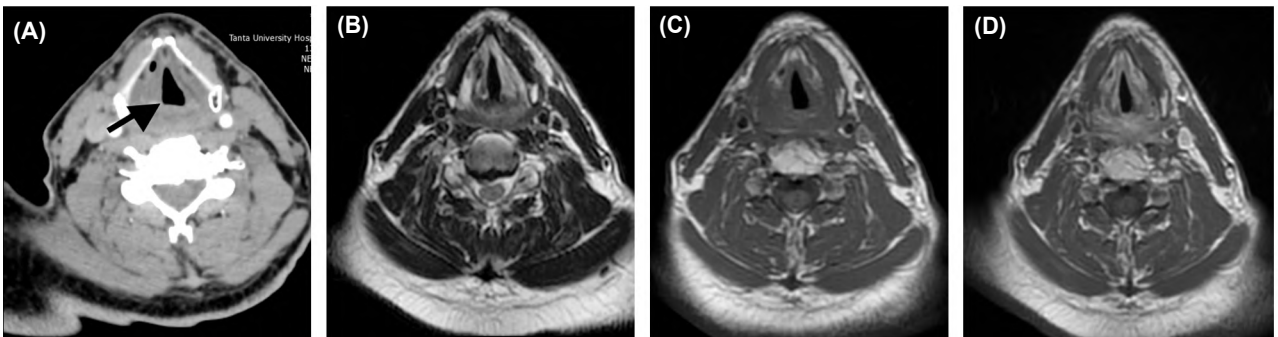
(A, B, C and D); A Male patient aged 55 years presented with hoarseness of voice. (A) Post-contrast CT axial view at the glottic region, (B) Axial T1-weighted image. (C) Axial T2-weighted image. (D) Axial post-contrast T1-weighted image. CT neck with contrast revealed asymmetrical right vocal cord thickening (arrow), no invasion of thyroid cartilage, anterior or posterior commissures. (A) On MRI mild thickening of the right vocal cord is noted (arrow) with preserved fat signal of the ipsilateral paraglottic space (B) A note is done for the homogenous signal of the vocal cord at normal side when compared to heterogeneous signal on the affected side (C) with relative enhancement of both vocal cords that seen slightly heterogeneous on the right side (D).
